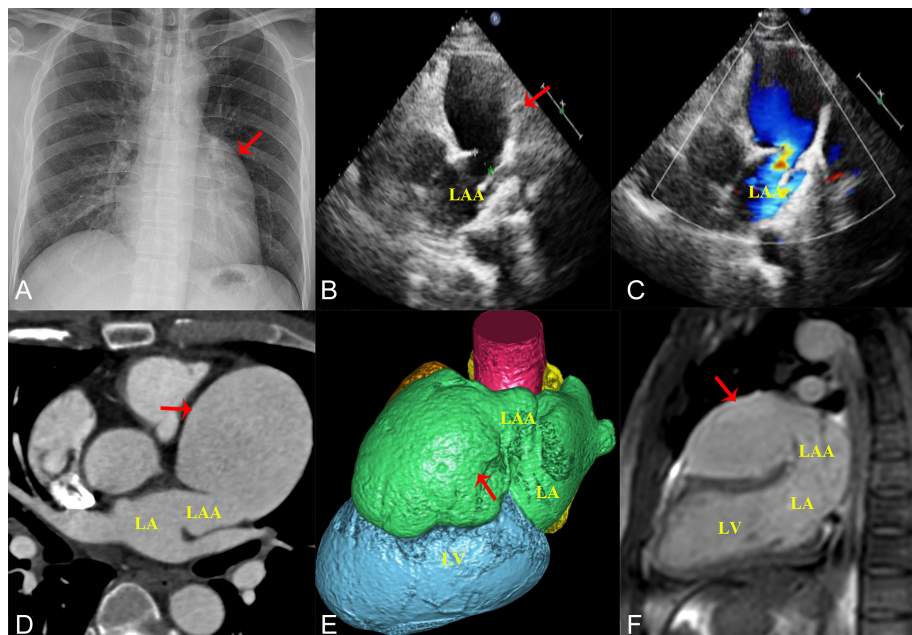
(A) Chest x-ray demonstrates a prominent outpunching of the left cardiac border inferior to the left hilum. (B and C) Transthoracic echocardiography shows a large left atrial appendage aneurysm (6.6 × 5.6 cm) widely communicating with the atrial cavity via a 1.6-cm aneurysmal neck. (D and E) Coronary CT angiography shows a giant saccule-shaped LAAA located anterior superior left ventricle. (F) CMR confirmed a giant aneurysm arising from the left atrial appendage compressing the banana-shaped left ventricle. LA, left atrium; LV, left ventricle; LAAA, left atrial appendage aneurysm; CT, computed tomography; CMR, cardiac magnetic resonance
